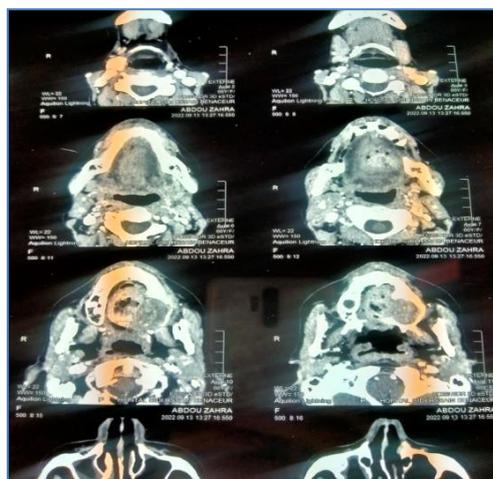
A facial CT scan revealed a mass on the left palate infiltrating the maxillary alveolar bone and the floor of the homolateral maxillary sinus and nasal cavities
